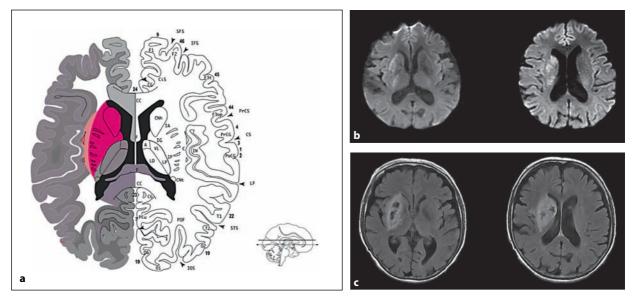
a Arterial mapping of the lenticulostriate territory (from Tatu et al. [4]). b Lenticulostriate infarct in DWI sequence. c Lenticulostriate infarct in FLAIR sequence.
